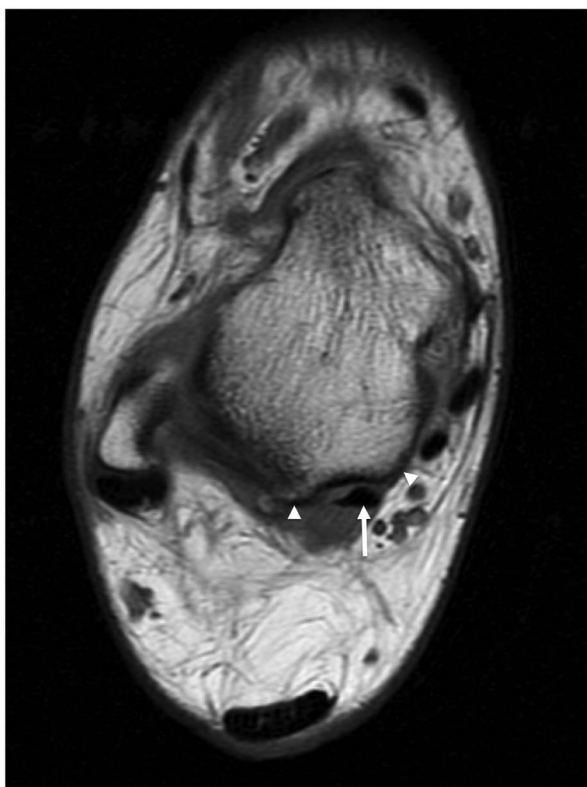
Normal anatomy. Axial T1-weighted MR image at the level of talus showing normal ankle flexor tendon anatomy with flexor hallucis longus tendon (arrow) interposed between the medial and lateral tubercles of the posterior talar process (arrowheads). The lateral tubercle is posterior, often more prominent, and easier to identify on lateral radiographs.
